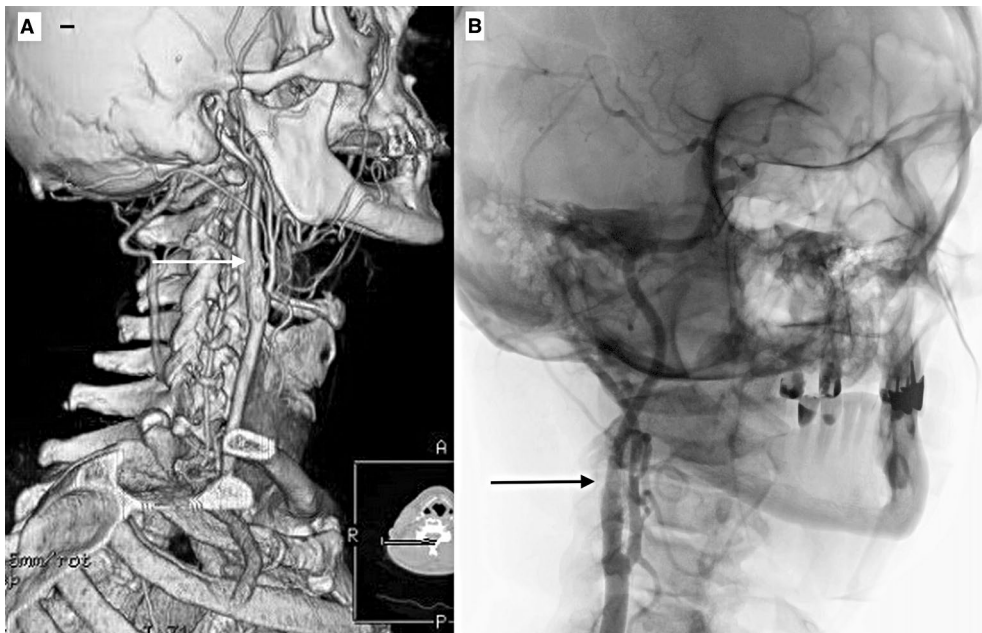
A — computed tomography angiography of the right carotid arteries — 10 years after RICA stenting. White arrow — a place of the retained filter; B — angiography of the right carotid arteries — 8 years after RICA stenting. Black arrow — a place of the retained filter
